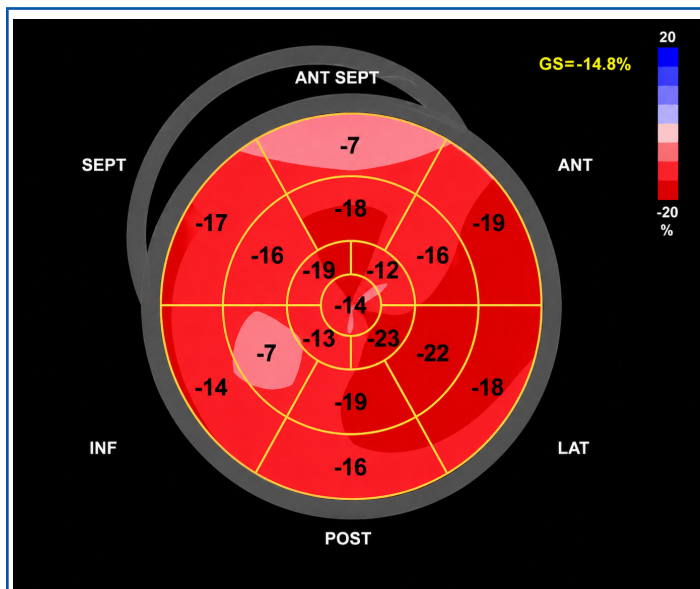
Transthoracic 2D speckle tracking echocardiography showing global reduced LV strain. 2D, two-dimensional; LV, left ventricular.
